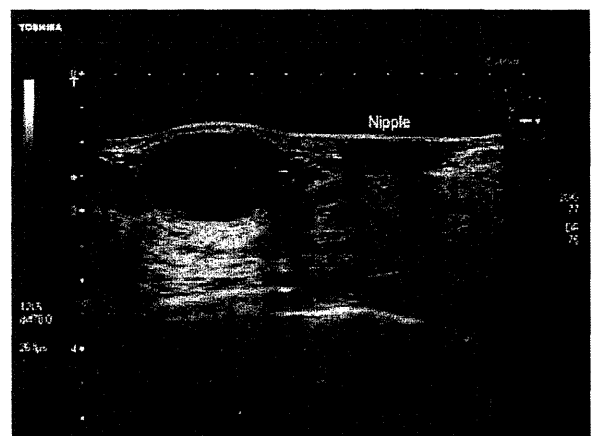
Ultrasonography showing a well-circumscribed, hypoechoic mass with a heterogeneous internal echo.
